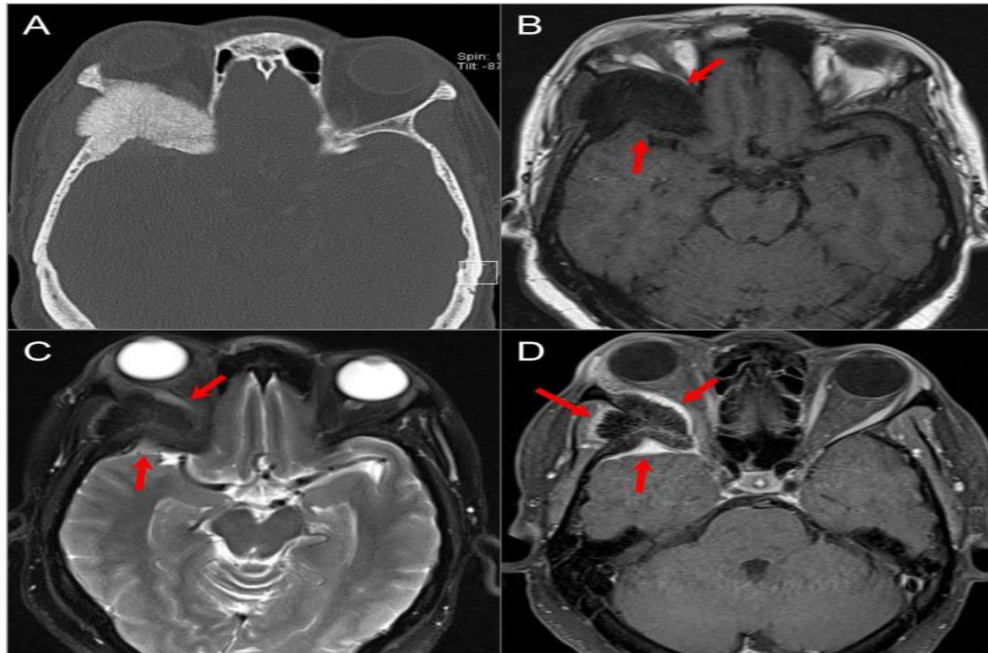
Intraosseous meningioma. (A) Axial CT shows a marked osseous expansion of the right posterolateral orbital wall and a greater wing of the sphenoid with a spiculated appearance. (B) Axial T1W and (C) STIR T2W images show marked hypointensity in the lesion with thin surrounding soft tissue components along the lateral orbital wall and temporal fossa (arrows). (D) Axial fat-suppressed postcontrast T1W image demonstrates heterogenous transosseous enhancement and avid contrast enhancement in the soft tissue components of the lesion along the temporal dura and orbital/temporal periosteum (red arrows). There is associated displacement of extraocular muscles and proptosis. (Casselmann *et al.*, 2019).
